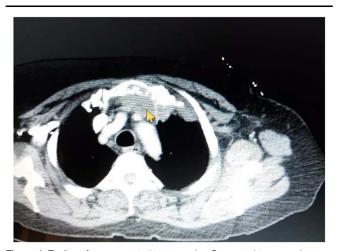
Findings from computed tomography. Computed tomography scan at the level of sternum mandible shows the cancerous lesion in the superior and anterior mediastinum with lateral pleural thickening at the left side (arrow).
